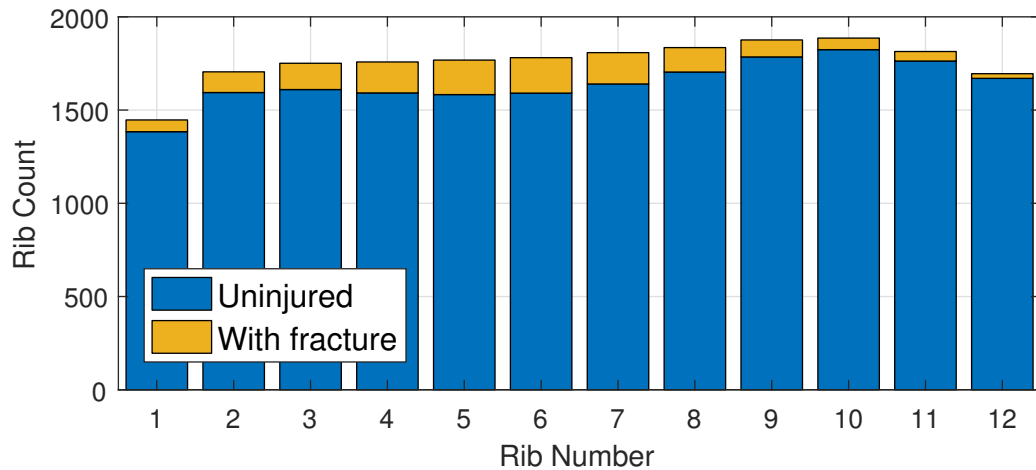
Counts of uninjured (included) and fractured (excluded) adult ribs present in study CT scans.
